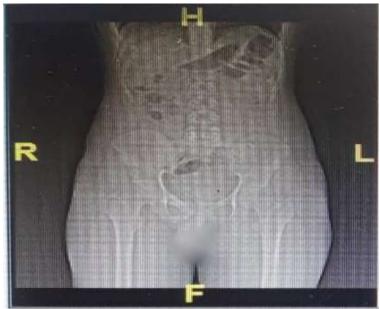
Multi slice spiral CT Pelvis: Topogram0.6.
